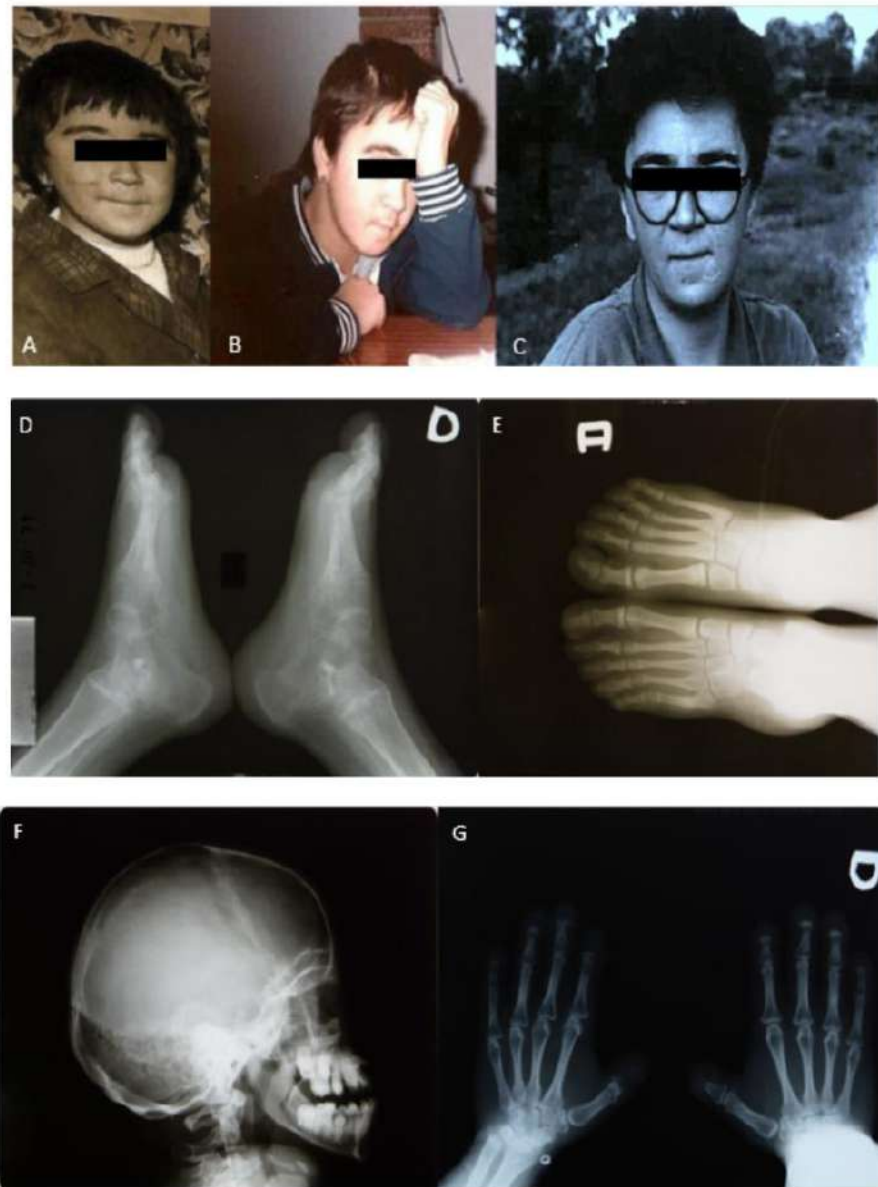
Childhood photographs. Radiologic controls 1977–79. (A–C) Portraits of childhood. (D) Lateral anteroposterior X-ray of the feet in 1977. (E) Frontal X-ray of the feet in 1977. (F) Lateral X-ray of the skull in 1978. (G) Frontal X-ray of the hands in 1979.
